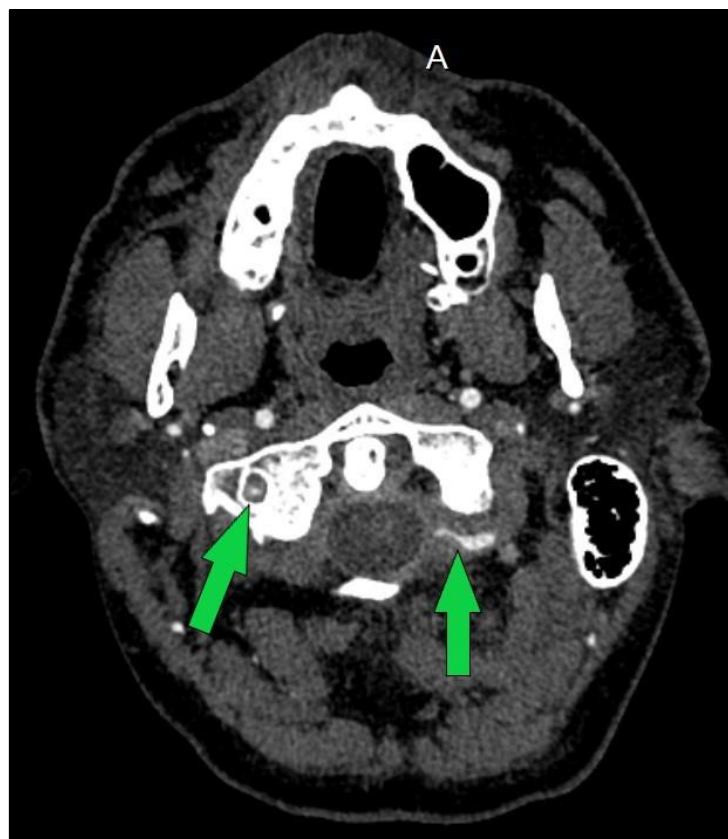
CTA neck examination showing change in vascular caliber of distal V3 segment of left vertebral artery. (right arrow)
